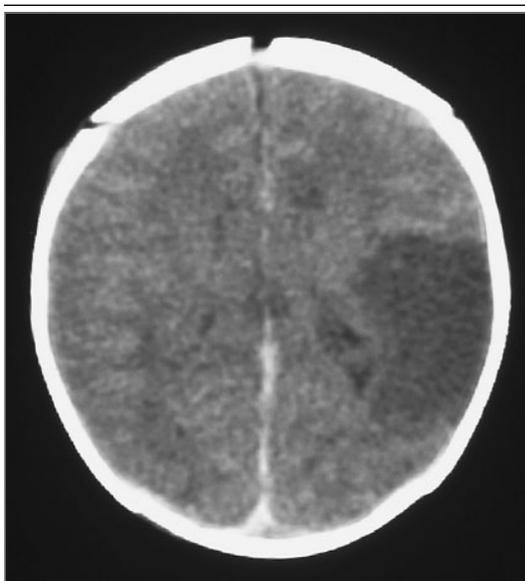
Axial Section of a Non-Contrast-Enhanced Cranial CT Scan Obtained on the Infant's Second Day of Life.
